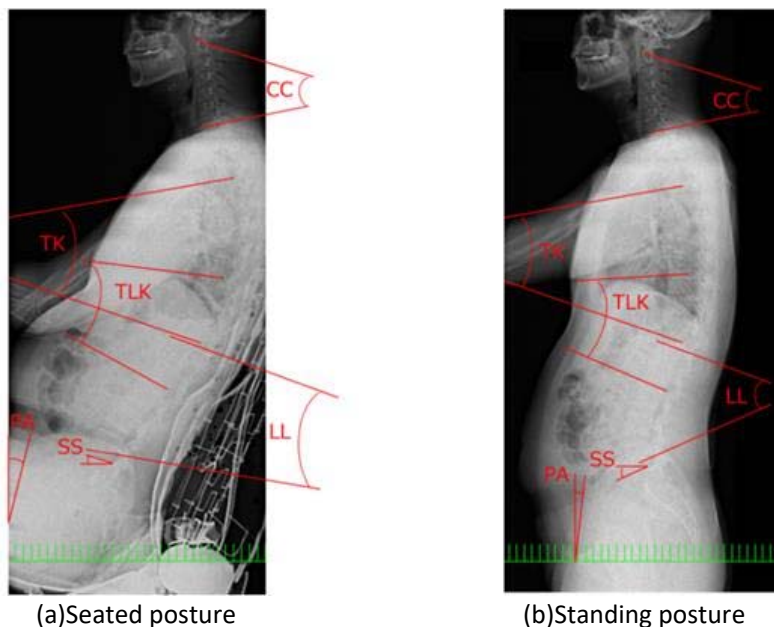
X-ray images of seated and standing postures with each angle for the spine and pelvis.
